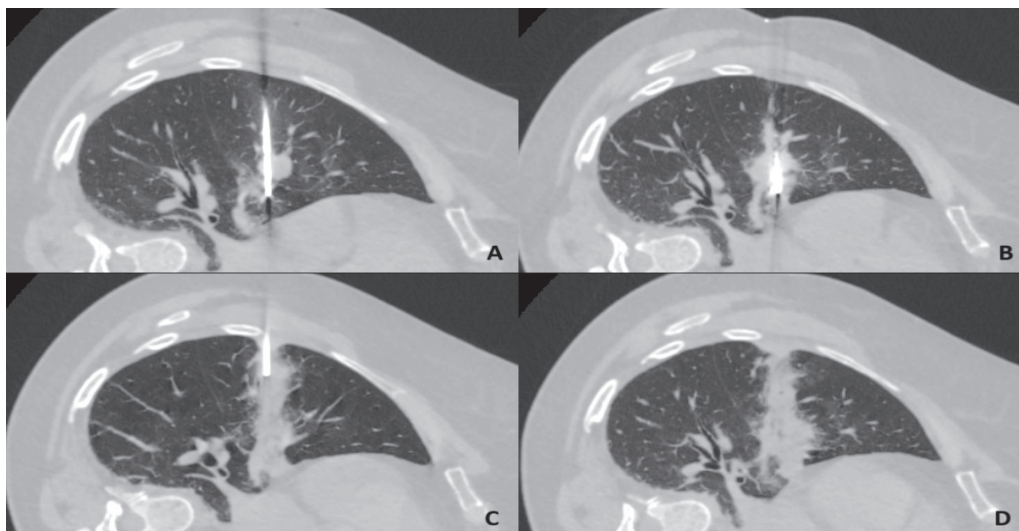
CT-guided lung microwave ablation procedure with tract sealing using clotted autologous blood. (A): Right lung middle lobe tumor penetrated by ablation antenna. (B): Ablation procedure with the formation of a consolidation zone. (C): Ablation tract sealing by injecting autologous blood clot while retracting the coaxial needle. (D): Fully sealed ablation tract—focal parenchymal consolidation is present through the entire distance of the transected lung. CT—computed tomography.
